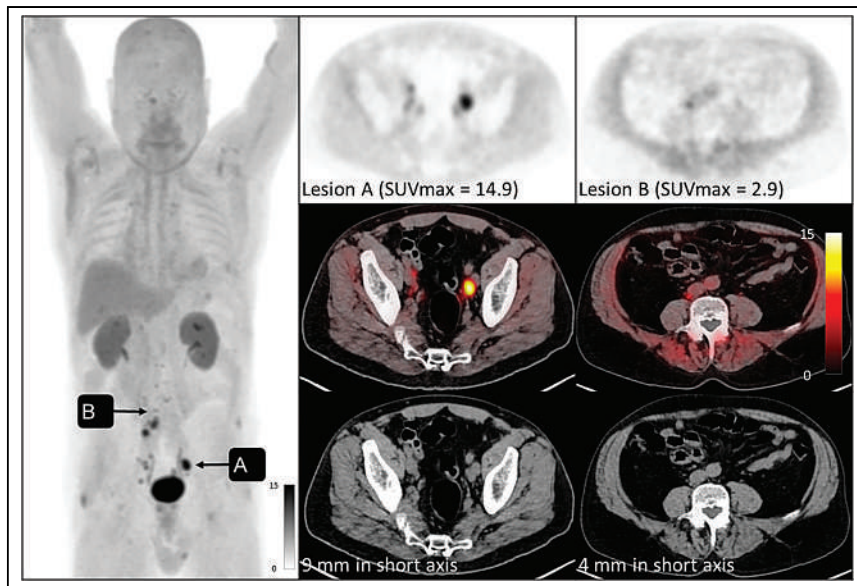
78-y-old man presenting with lymph node–negative, localized MIBC on initial staging ^{68}Ga -FAP-2286 PET (top and maximum-intensity projection at left), PET/CT (middle), and CT (bottom). Imaging revealed multiple paracaval and pelvic lymph nodes (denoted by arrows). Patient underwent radical cystectomy with extended lymph node dissection, which confirmed spread of cancer at time of surgery.
